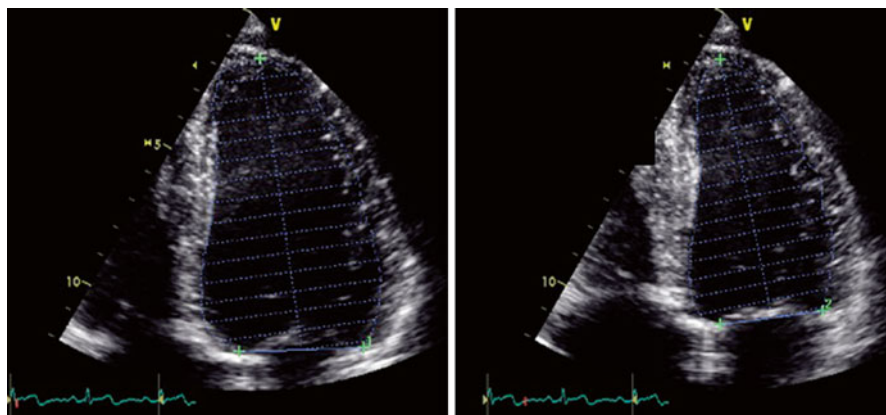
The assessment of left ventricular systolic function using biplane Simpson's technique which involves planimetry of the endocardial border in end diastole (*left*) and end systole (*right*) in apical 4 chamber view. This measurement is then repeated in apical 2 chamber view which then allows automatic calculation of ejection fraction
